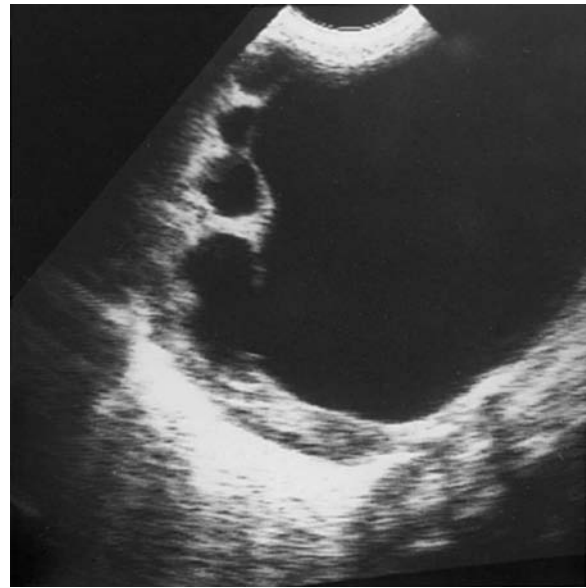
Ureteropelvic junction obstruction. A newborn with left flank mass. Ultrasonography of the left flank shows dilated pyelocalyceal system. The communicating dilated collecting systems are seen in the periphery of the significantly dilated renal pelvis.
